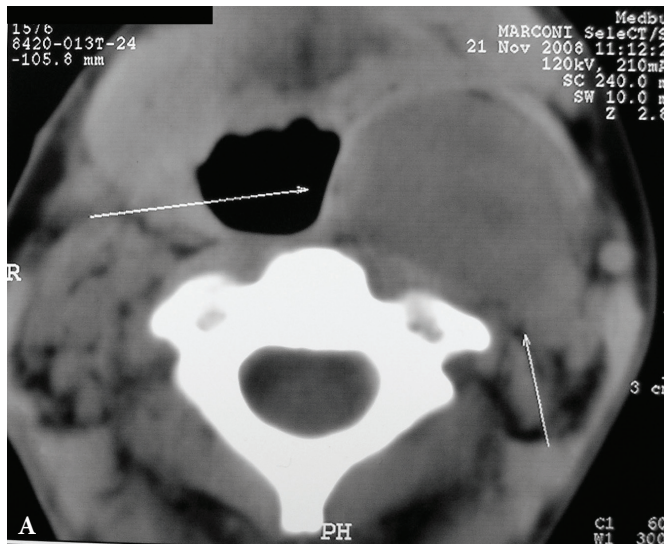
Computed tomography (A) of patient with carotid chemodectoma (arrows). Operating wound after chemodectoma removal (B). Common carotid artery – white arrow, greater horn of hyoid bone – yellow arrow. Macroscopic view of chemodectoma at section (C).
